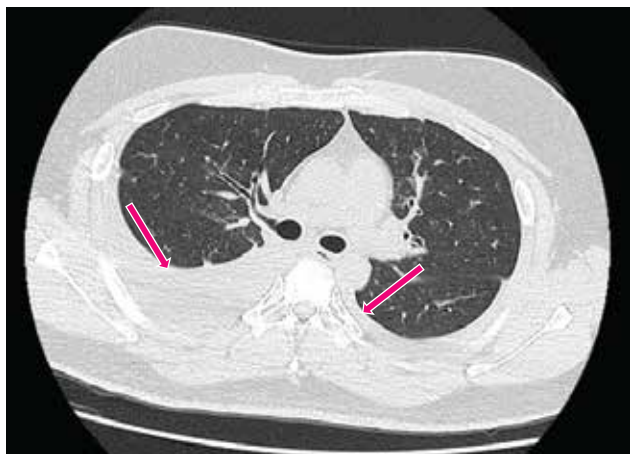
Axial section of the CT scan of the chest showing moderate right-sided pleural effusion and mild left-sided pleural effusion (arrows) and GGO on the left apicoposterior segment of the upper lobe.
